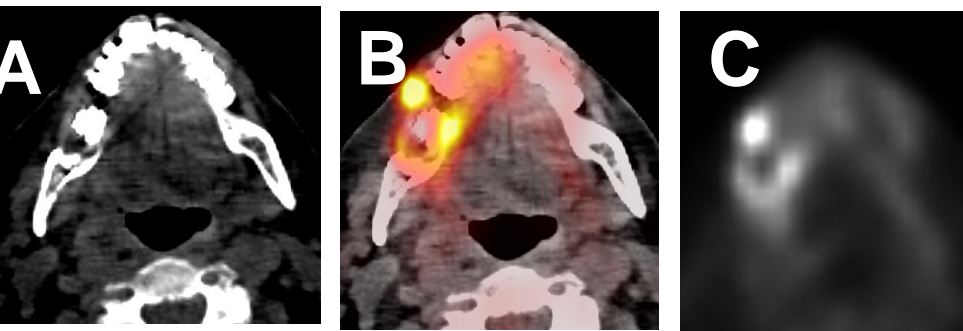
axial CT, B, C, Axial PET-CT false positive from infected right first mandibular molar tooth
